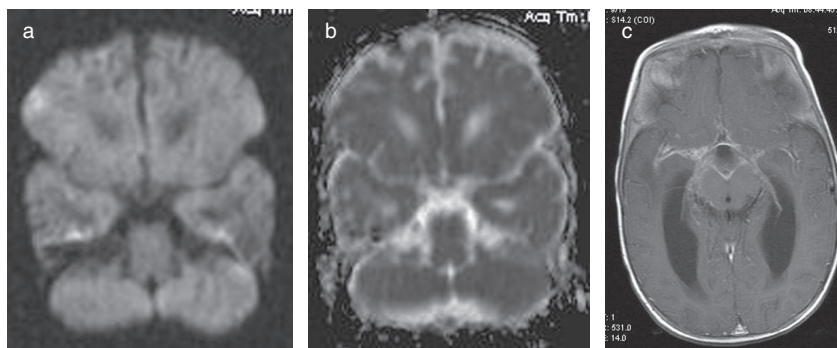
Bilateral temporal borderzone necrosis associated with severe right and mild to moderate left basal meningeal enhancement. (a) DWI demonstrates subtle increased signal involving the temporal cortex adjacent to the MCA cistern bilaterally. (b) ADC mapping confirms restricted diffusion at both sites. (c) Gadolinium enhanced T1 MRI demonstrates severe enhancement in the right MCA cistern and mild to moderate enhancement lining the left MCA cistern. ADC, apparent diffusion coefficient; DWI, diffusion-weighted imaging; MCA, middle cerebral artery.
